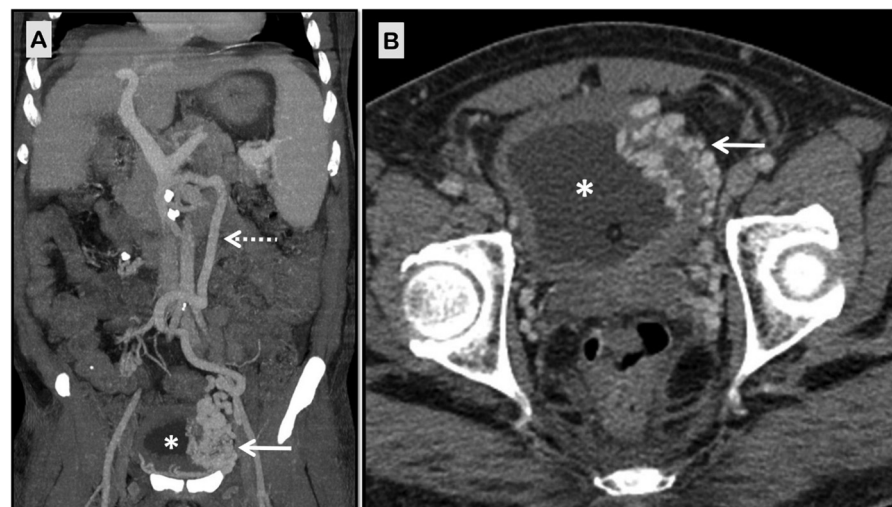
Coronal maximum intensity projection (A) and axial (B) venous phase computed tomographic images of the abdomen of the patient demonstrating a dilated and tortuous inferior mesenteric vein (IMV; dashed arrow in A) supplying a bunch of vesical varices (solid arrows in A and B). Asterisk denotes the urinary bladder lumen.
